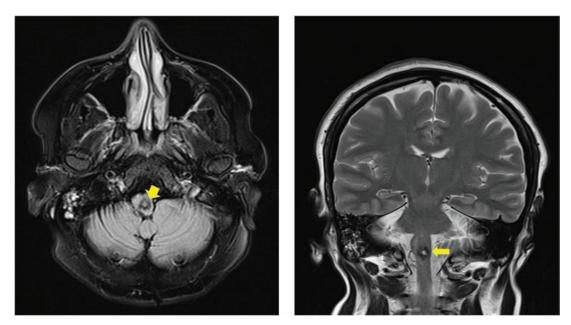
Chronic hemorrhage in the medulla (yellow arrows) secondary to cavernous malformation. (A) Brain MRI axial FLAIR sequence. (B) Brain MRI coronal T2 sequence.
